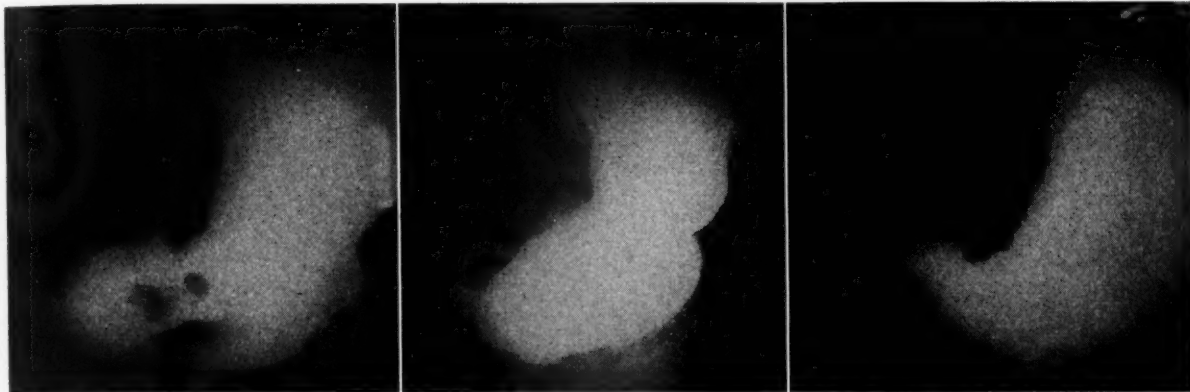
Case 3. *a*, Original examination. *b*, Normal appearing stomach. Radiograph made in different positions than others. *c*, Eighteen months later.
